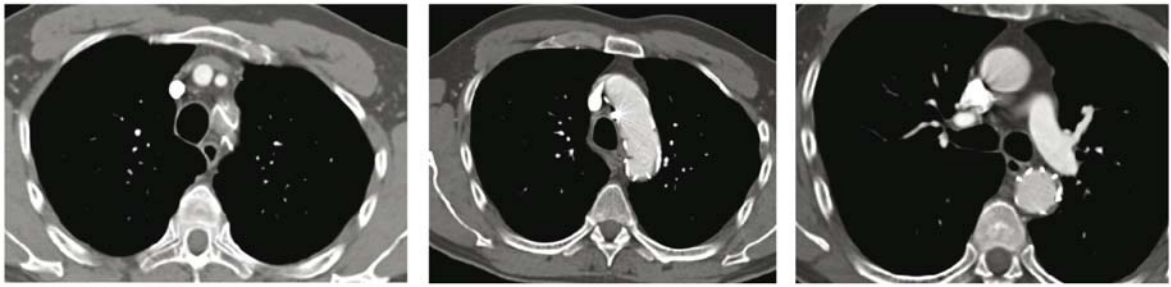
The CT control at 1 year demonstrates the complete healing of the aortic wall, without any endoleak. Note the intentional exclusion of the left subclavian artery, with a reverse
